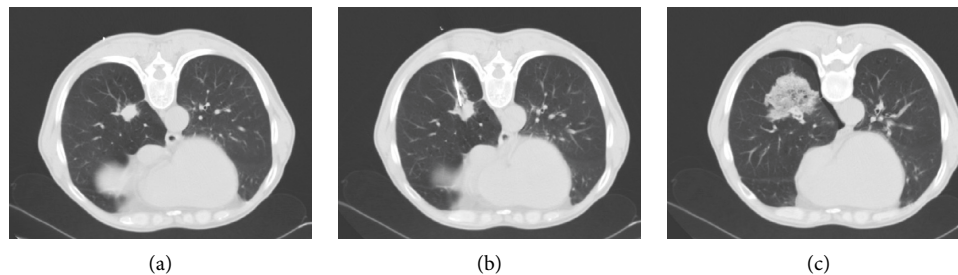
Pulmonary hemorrhage after CT-guided core needle biopsy.
